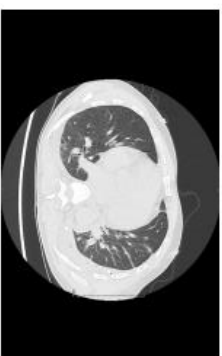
CT chest on day 8 after chest tube placement and tPA
